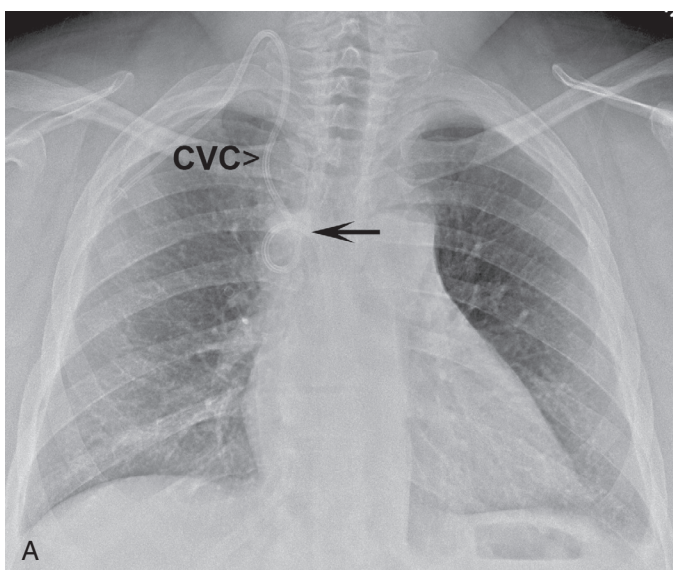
■ A, Posteroanterior (PA) chest x-ray. Placement of a central line (CVC) in the azygos vein. Arrow depicts the coiled CVC in the region of the azygos vein. B, Corresponding lateral chest x-ray. Note how the CVC takes a 90-degree posterior turn into the azygos arch (AA) before taking a 90-degree inferior turn into the descending azygos vein (DAV).
